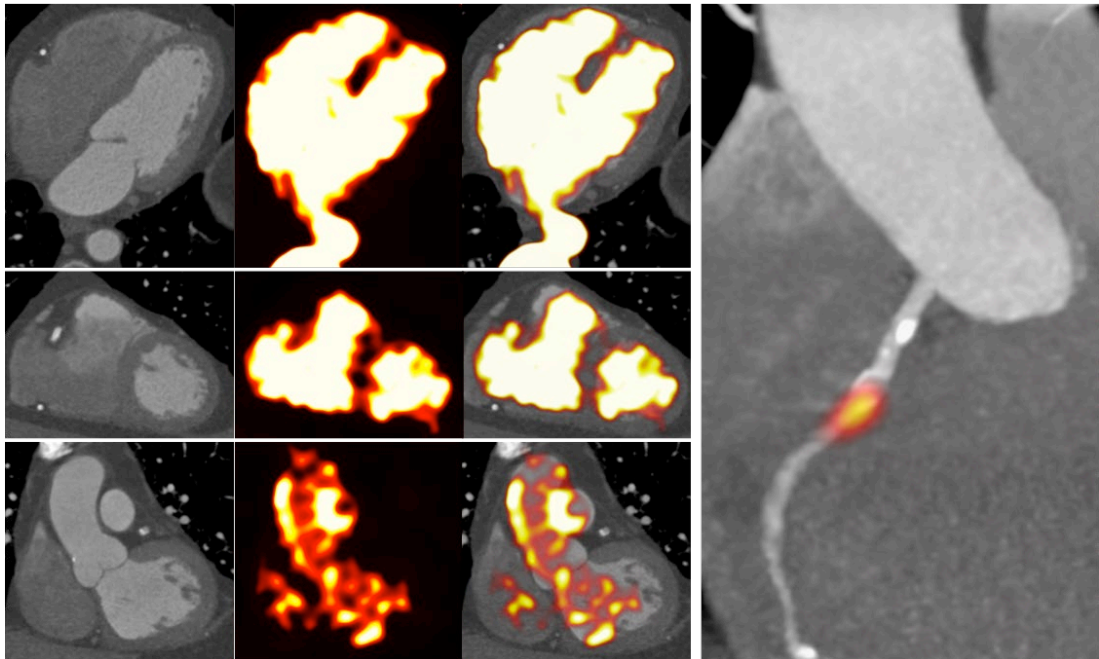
Co-registration of ^{18}F -fluoride positron emission tomography with contrast-enhanced computed tomography.
